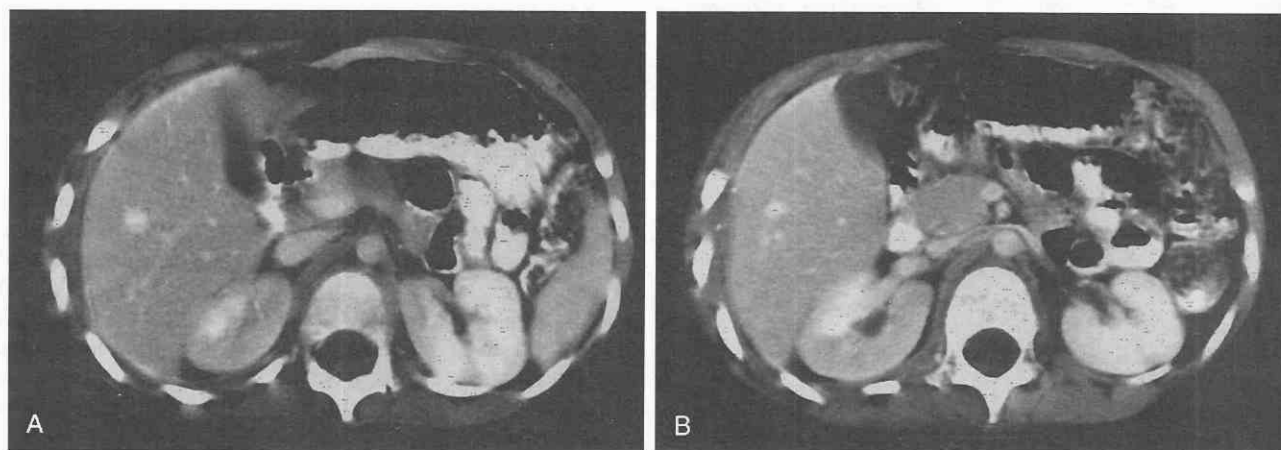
Subacute radiation nephritis in a 5-year-old girl who had recent radiation therapy for an undifferentiated sarcoma of the posterior right eleventh rib. Contrast-enhanced CT axial images through the upper poles (A) and hila (B) of the kidneys. A very sharply defined, nonsegmental, homogeneously low-attenuation band of nonenhancement extends through most of the upper pole of the right kidney and the medial portion of the upper pole of the left kidney. There is also thickening of the soft tissues of the right lateral chest wall and over the lateral margin of the liver.
